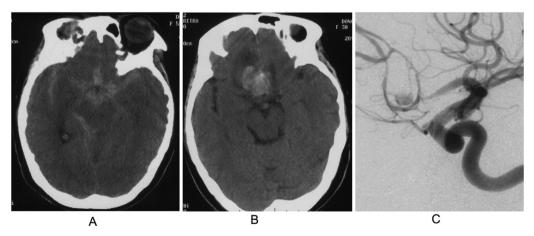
Case 1. (A) Axial CT scan at onset showing subarachnoid hemorrhage. (B) CT scan at presentation in our center showing a new derived hematoma. (C) Left internal carotid artery angiogram showing an irregular-bordered ACoA aneurysm.
